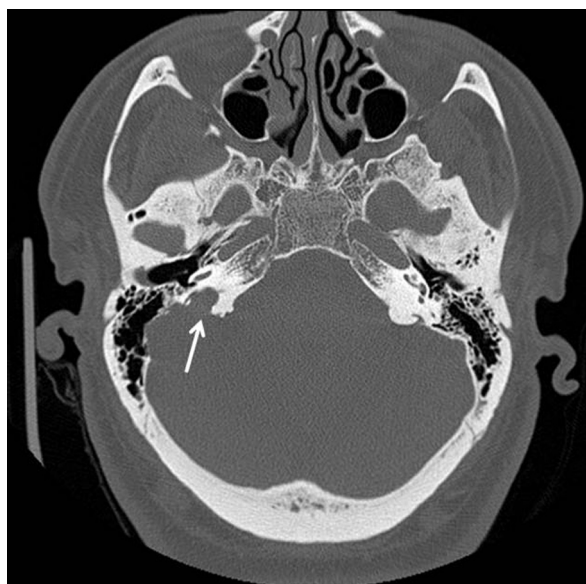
An axial computed tomography scan without contrast showing marked endosteal scalloping of the right posterior petrous bone at the cerebellopontine angle (arrow) and a slightly enlarged adjacent vestibular aqueduct with respect of mastoid.
